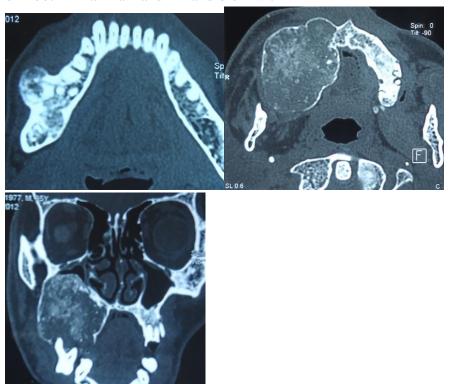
showing cropped CT scan images showing opacity in right side of body of mandible and maxilla with displacement of walls of maxillary sinus
